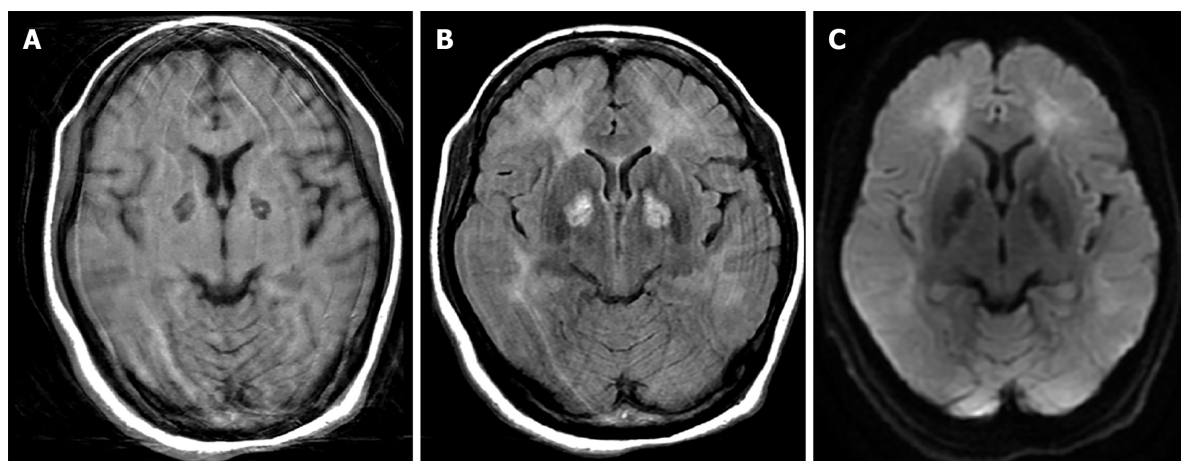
Brain magnetic resonance images of the patient. A: Axial view of T1-weighted image shows low signal of bilateral globus pallidi, with a tiny high signal indicating minor hemorrhage; B: T2-Fluid-Attenuated Inversion Recovery image shows hyperintensities of bilateral globus pallidi and diffuse leukoencephalopathy in subcortical white matter of the bilateral frontal and occipital lobes; and C: Diffusion-weighted image shows increased diffusion signals. Artifacts were caused by the patient's movement during image acquisition.
